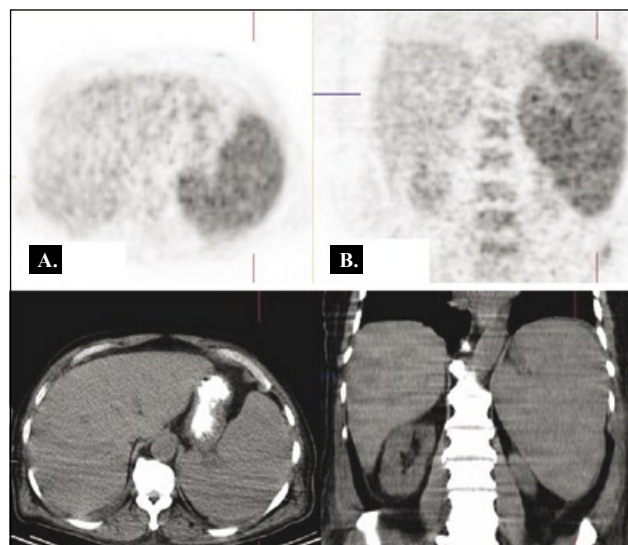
Transaxial (A) and coronal (B) FDG-PET/CT images revealed hyperplasia and an increased diffuse heterogeneous ^{18}F -FDG uptake in the spleen 2.5 times intense than the liver. There was no evidence of involvement of lymph nodes, bone marrow or any other organ.
